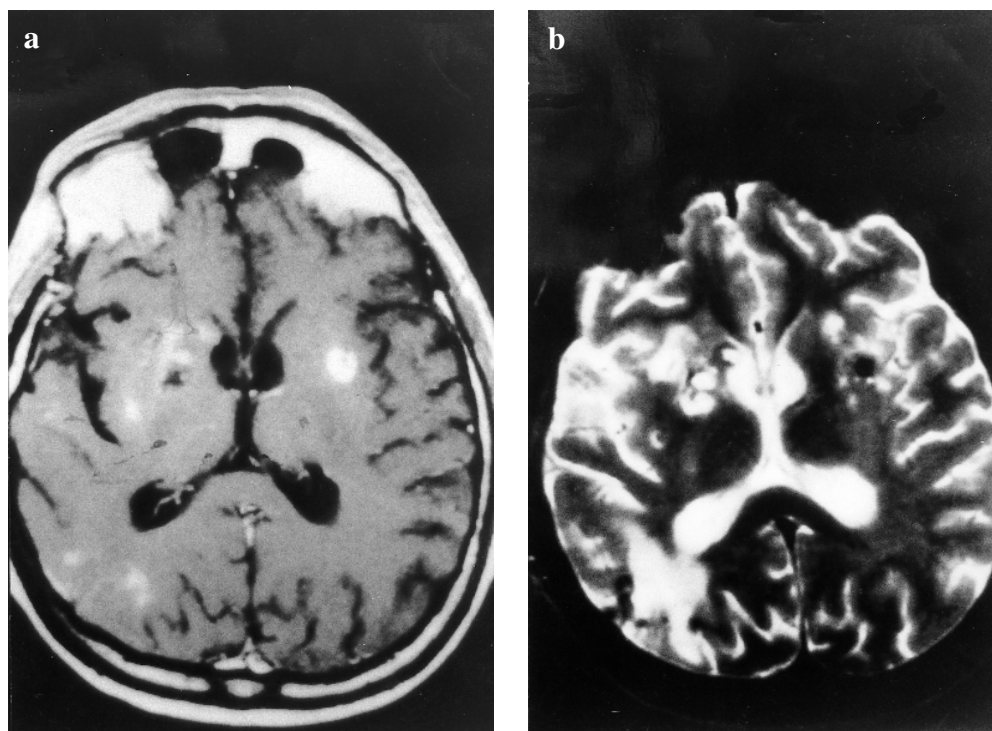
Axial MRI images in the acute phase of toxoplasmosis. Abscess involving the left lenticular nucleus. Inflammatory lesions in right basal ganglia. a T1-weighted image. b T2-weighted image
